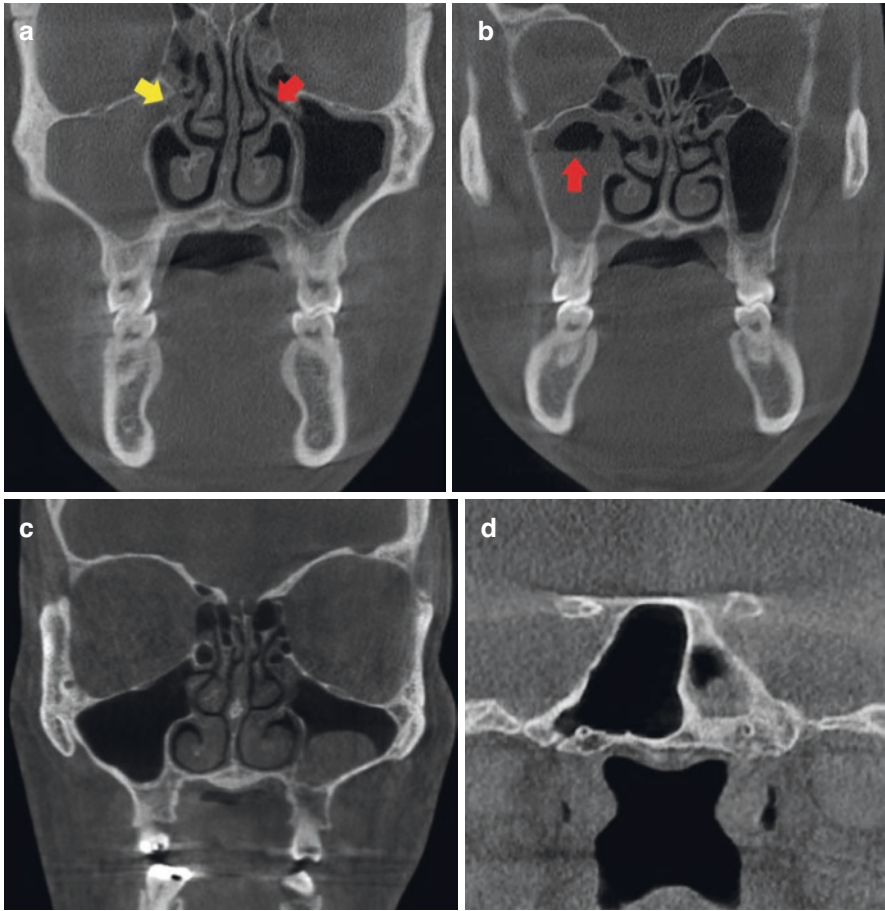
Coronal CBCTs of different patients show different presentations for sinus inflammation. (a) The right maxillary sinus is completely opacified by either fluid or soft tissue and blockage of the right ostiomeatal complex (yellow arrow). The left maxillary sinus shows even mucosal thickening that is parallel to the bony walls and a patent ostiomeatal complex (red arrow). (b) The right maxillary sinus shows an air/fluid level (red arrow) in the superior third of the sinus suggestive of fluid accumulation in acute sinusitis. (c) Mucus retention pseudocysts are a common finding in the sinuses that often require no intervention unless large and obstructing the drainage pathways. (d) Chronic sinusitis changes noted in the left sphenoid sinus. The sclerosis of the surrounding bone indicates a chronic low-grade inflammatory process
